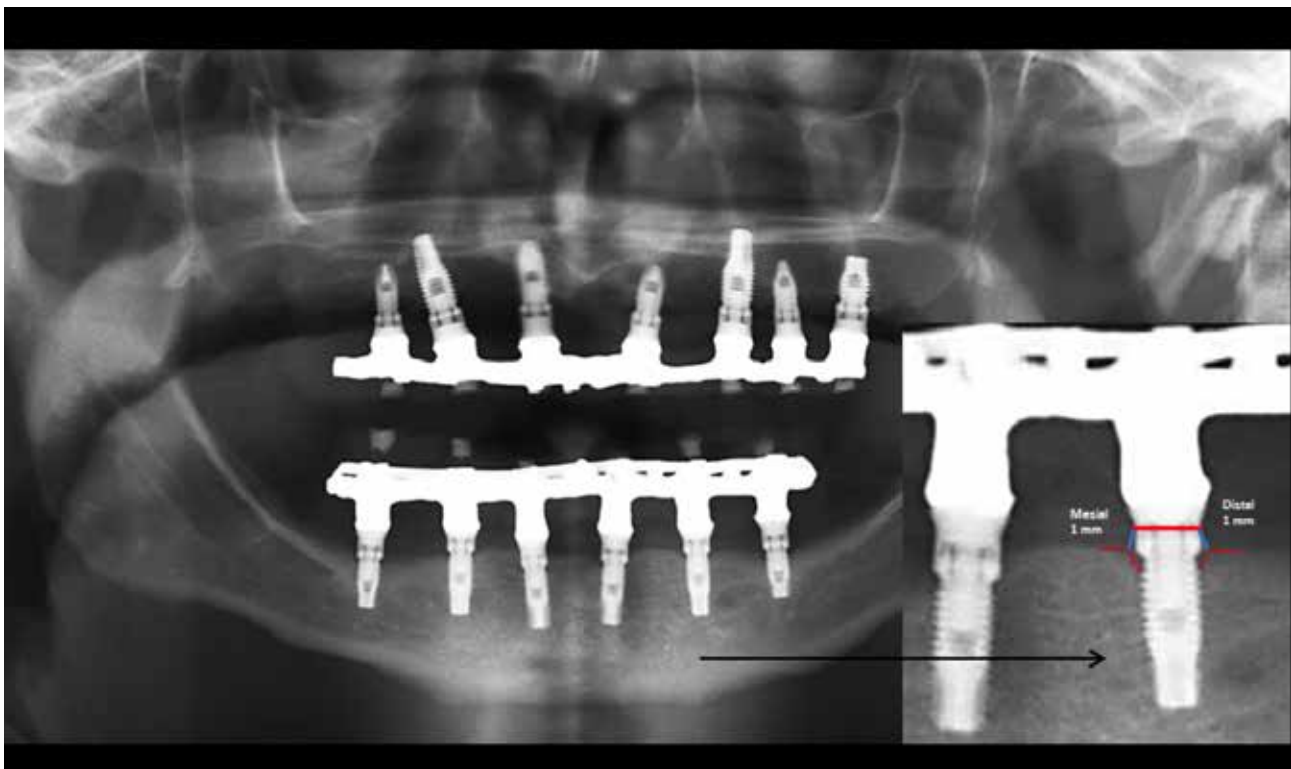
Demonstration of bone loss measurement between the mesial and distal alveolar crest to the edge of dental implant performed in digital panoramic radiograph.
